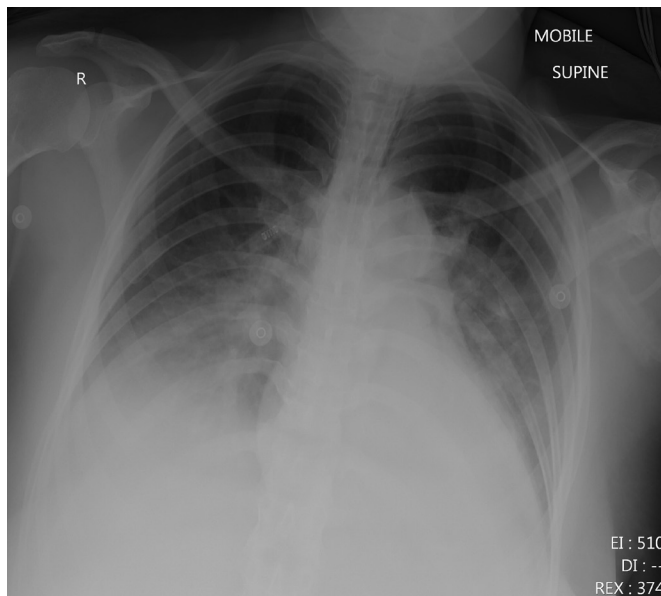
Chest radiograph showing bilateral perihilar and lower zone opacifications suggestive of pulmonary oedema. Date: 31 August 2021.
